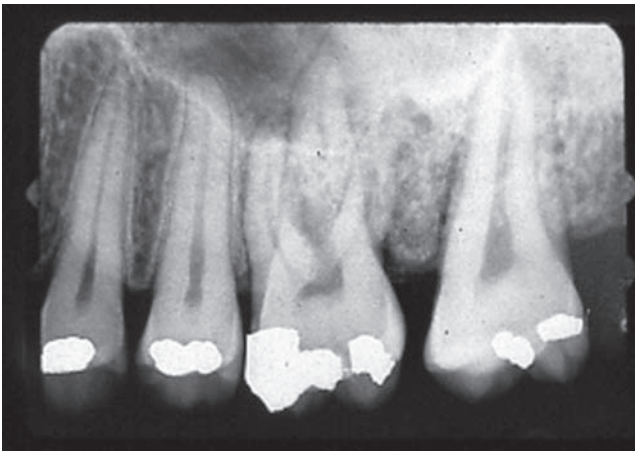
Widening of the periodontal ligament space. This radiograph is of a 34-year-old woman who was incorrectly treated for periodontal disease. Note the widened periodontal ligament space around the first molar. There is a separation between the first and second molar, and the interproximal alveolar bone has a mottled atypical appearance compared to what would be expected. A biopsy of the area between the two molars found osteogenic carcinoma. (Courtesy of Dr. John W. Preece.)
